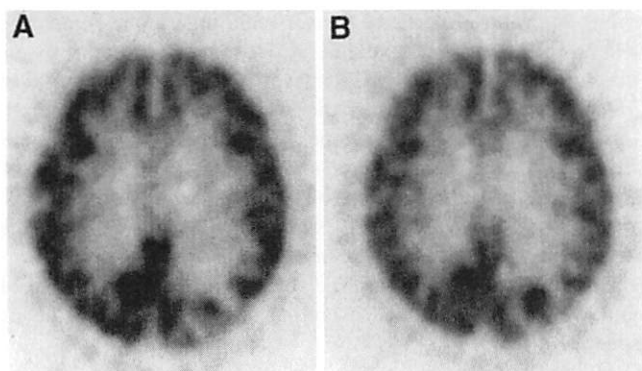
Pretreatment (A) and 4 h post-treatment (B) FDG PET images of patient with lung carcinoma (patient 1 in Table 1). Tissue activity images are shown. FDG accumulation of metastatic tumor in left parieto-occipital region, relative to that of gray matter, increased immediately after radiosurgery.
